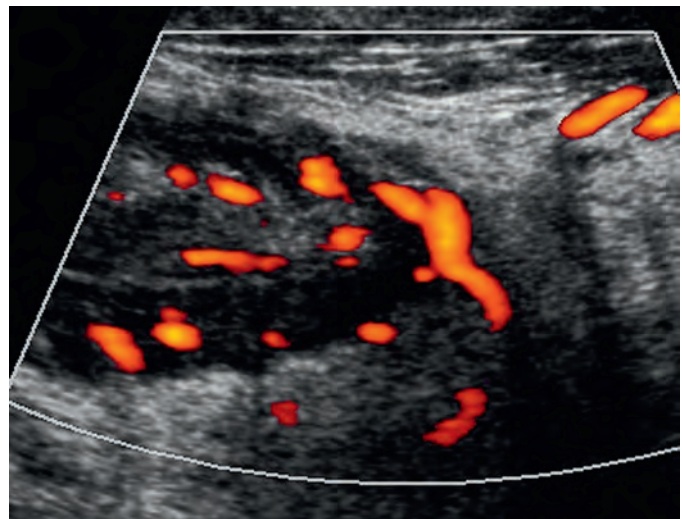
Acute ileitis in Crohn's disease. Power Doppler signals indicate hyperemia of acute, active, inflammatory CD ileitis.
